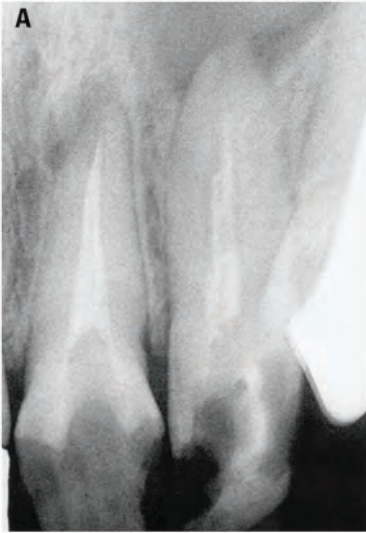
Root-end resection using laser energy. A, Pretreatment radiograph revealing failing endodontic treatments with periapical lesions. B, Radiograph following endodontic treatment and root-end resection of teeth #9 and #10 using an erbium: yttrium-aluminum-garnet laser. C, Twenty-six months postsurgical radiograph revealing good periradicular healing. Courtesy of S. Cecchini, Italy.
